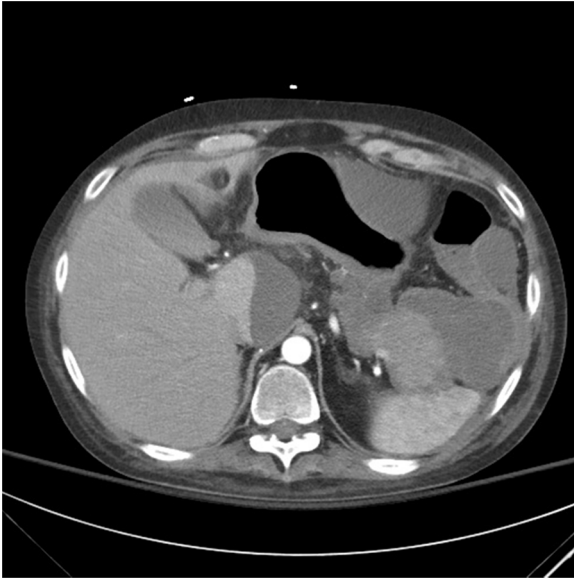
CT abdomen on hospital day 25, showing worsening pancreatic collection and new caudate lobe collection.
